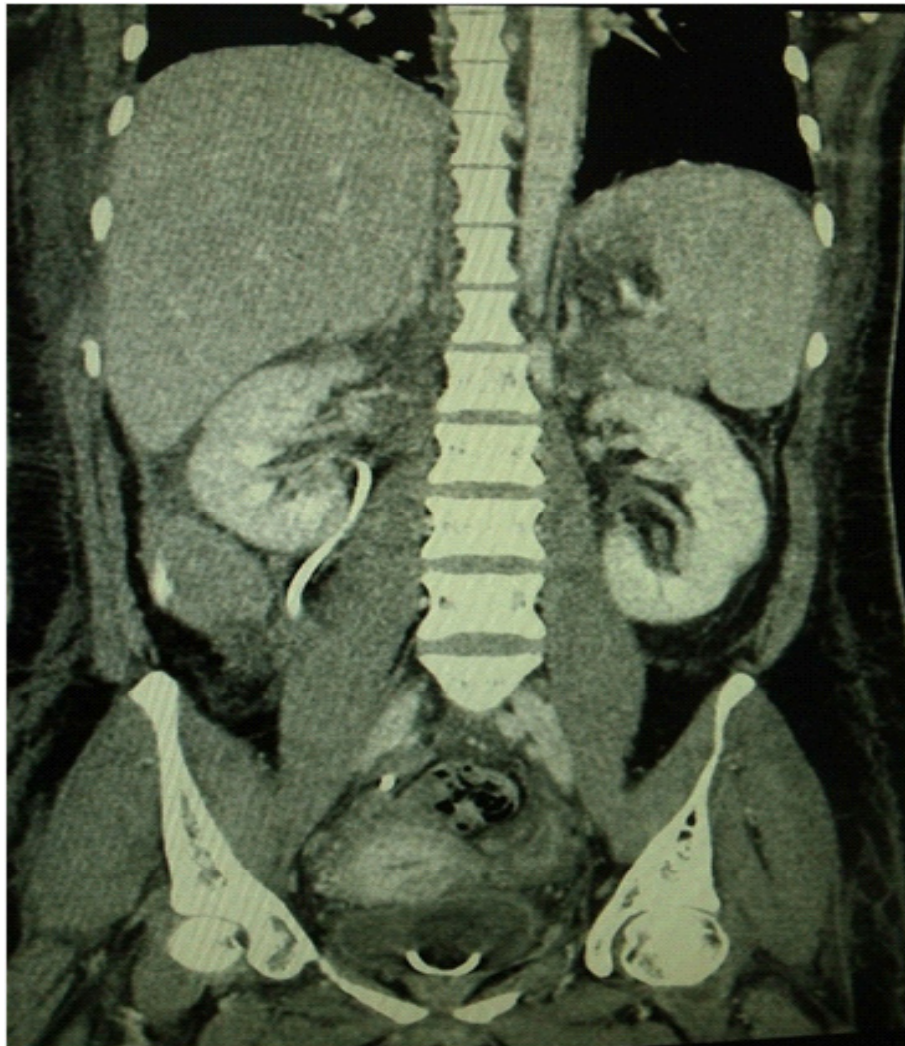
CT image post Appendix interposition repair showing the double J stent in-situ.
